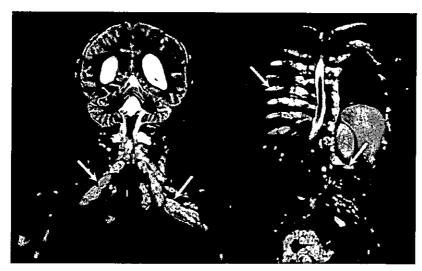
Plexiform neurofibromas in a 15-year-old boy with NF1. Coronal T2-weighted MR images of the head, neck, and chest show multiple T2-hyperintense plexiform expansions of a long nerve segment and its branches (arrows), compatible with plexiform neurofibromas.
